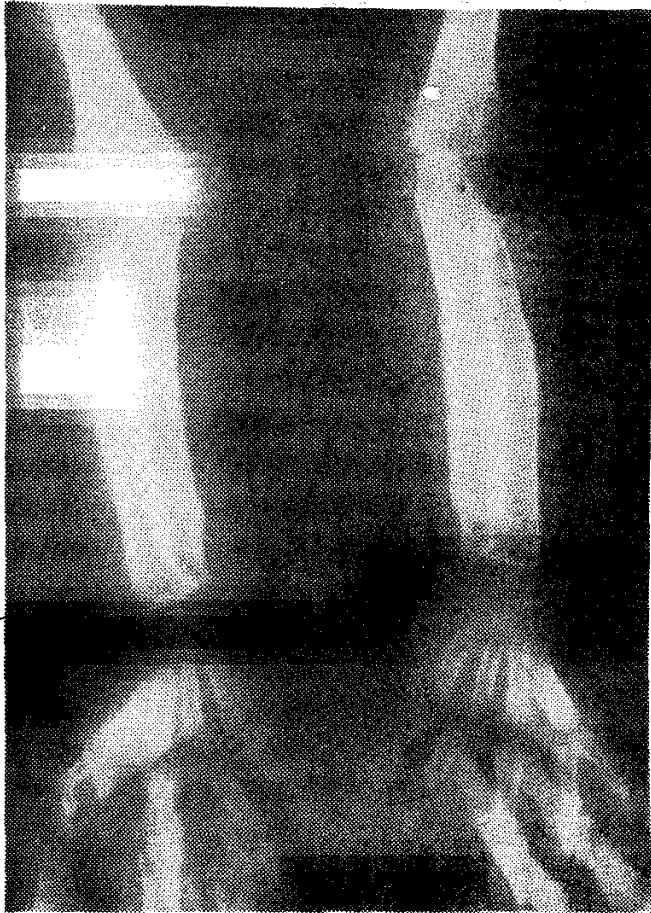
A-P radiograph of both forearms shows periosteal reaction along the shafts of radius and ulna.
